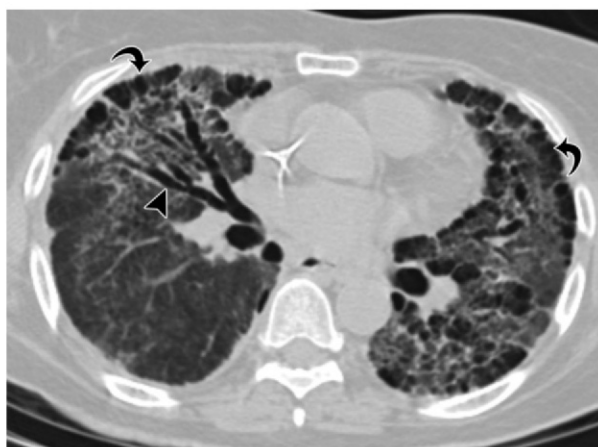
Atypical pattern of fibrosis secondary to DAD. (a) Axial CT image at the level of the right middle lobe in a 36-year-old woman with worsening shortness of breath demonstrates basilar-predominant GGO. Small subpleural cysts are seen due to underlying paraseptal emphysema (arrows). (b) CT image at the same level 4 days later shows diffuse GGO with more dependent consolidation in the right lower lobe. Bronchiectasis (arrowhead) has developed, and the cystic spaces (arrows) have enlarged. A transbronchial biopsy confirmed DAD. (c) CT image obtained 9 months after a shows a bizarre pattern of anterior-predominant fibrosis that is most severe in the middle lung zone. Bronchiectasis (arrowhead) has progressed, and subpleural (arrows) and parenchymal cystic changes are prevalent.
